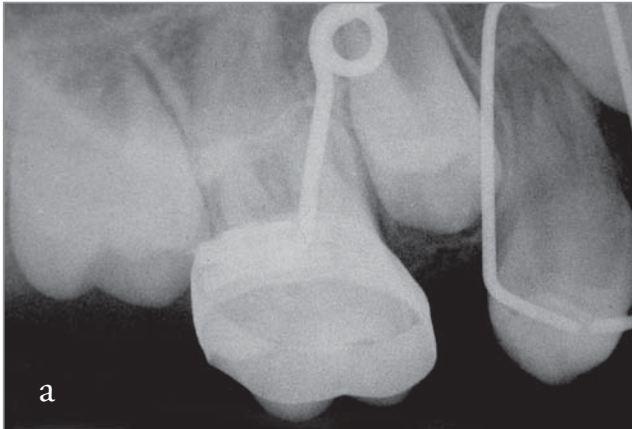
Initial and final periapical radiographs.
